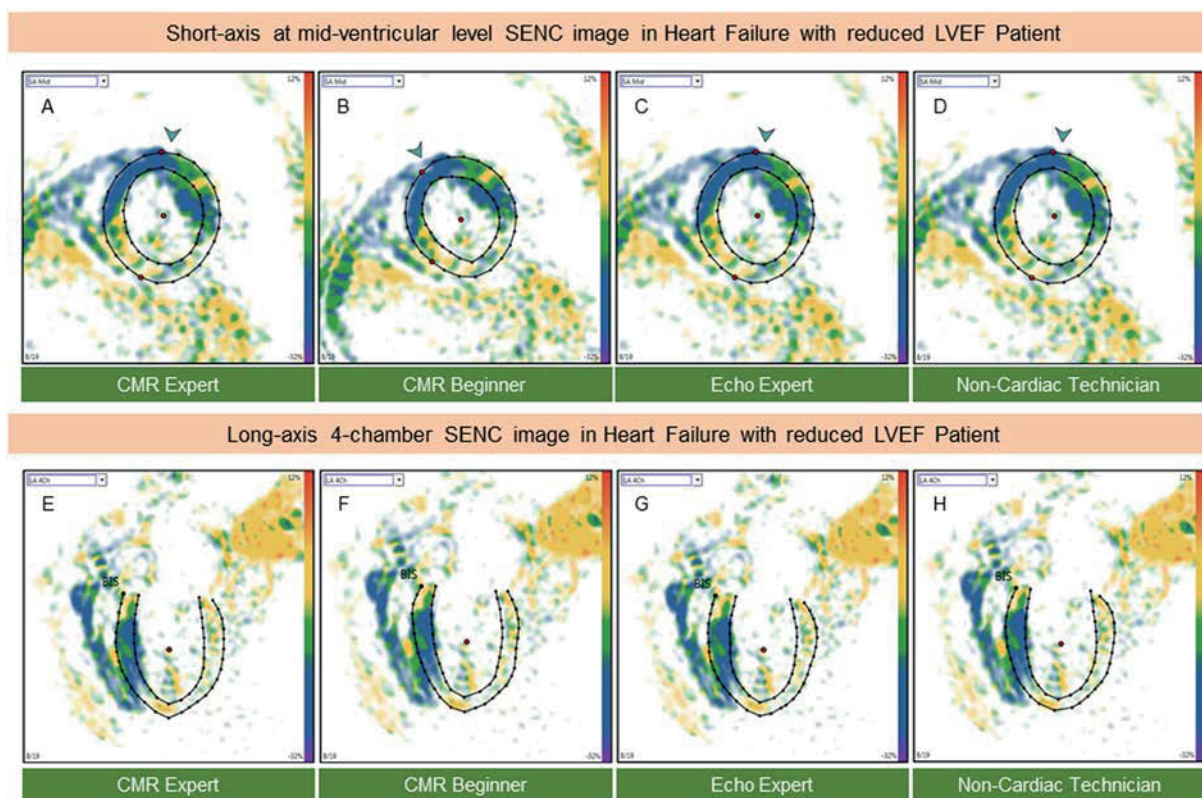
Example of fast-SENC images acquired in HFrEF patients and uploaded into a dedicated MyoStrain software. Endocardial and epicardial borders were traced at end-diastolic and end-systolic cardiac phases by four observers: CMR expert (A,E) CMR beginner (B,F) echocardiography expert (C,G) and non-cardiac technician (D,H). CMR = cardiac magnetic resonance; SENC = strain-encoded imaging; HFrEF = heart failure with reduced left ventricular ejection fraction.
